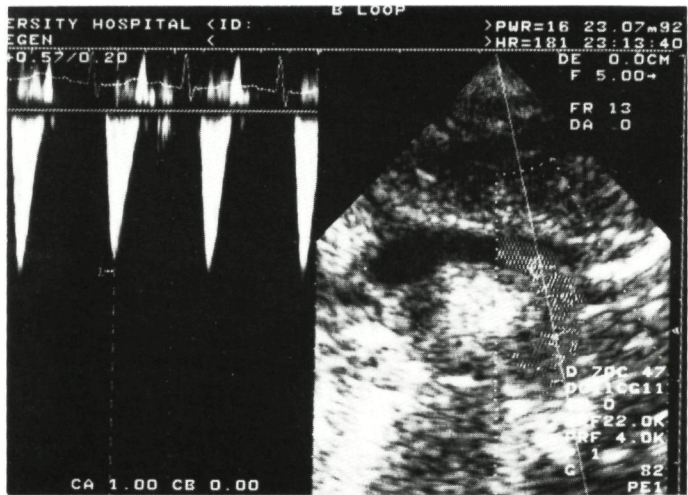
Echocardiographic image of the aorta before iniation of ECMO
